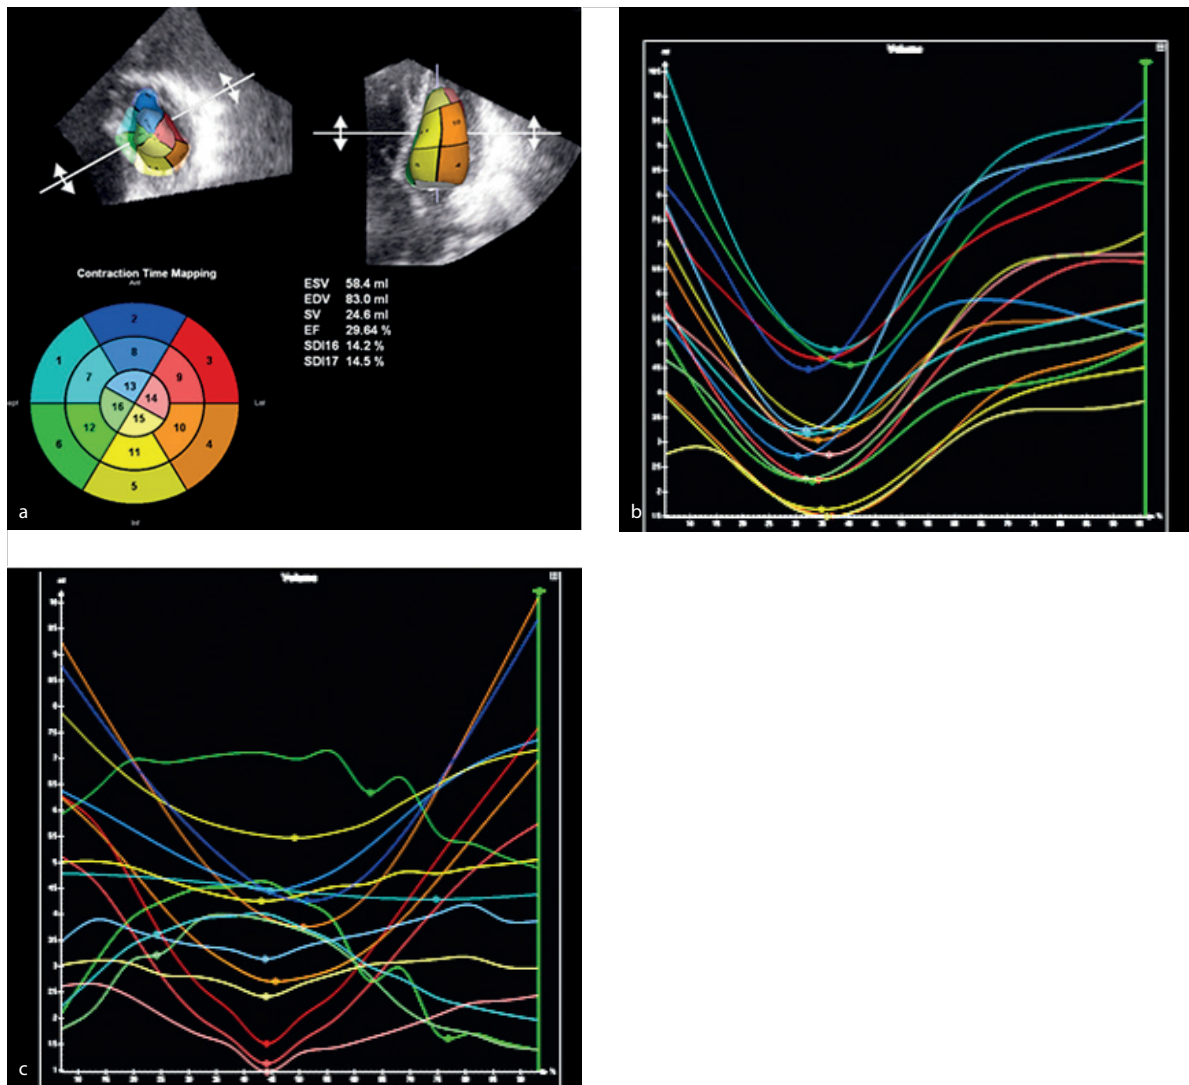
3-D echocardiography.
